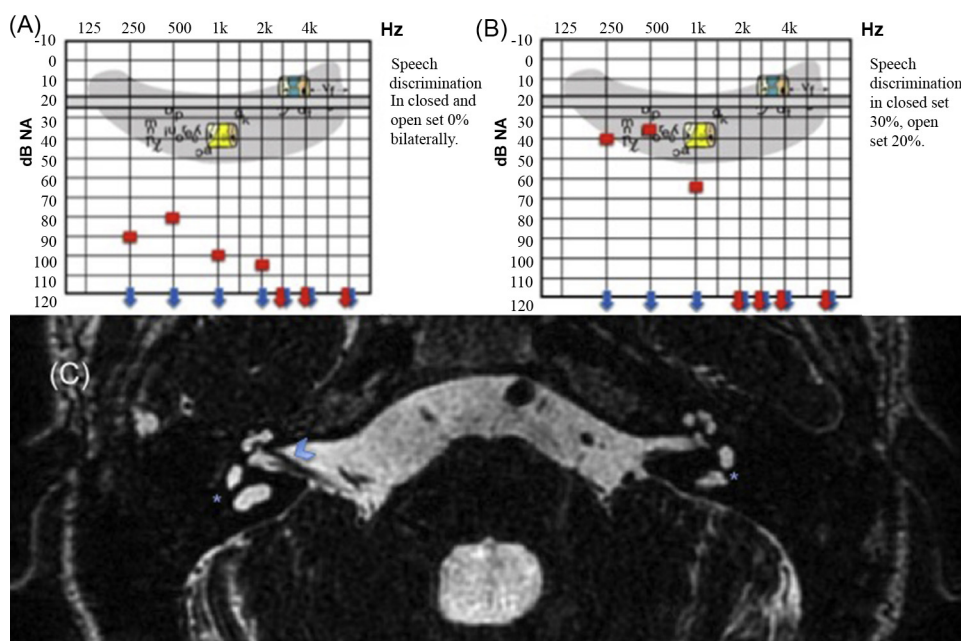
Audiometric and MRI findings prior to cochlear implantation. (A) Audiometric results without hearing aid. The patient showed no speech discrimination. (B) Audiometric results with a well-adapted hearing aid in the right ear. Speech discrimination thresholds in closed and open set are below 50%. (C) Axial MRI image of the right and left internal auditory canals showing a cochlear nerve in the right side (arrowhead) and absence of the cochlear nerve in the left, which correlates with auditory findings. The ★ shows the hypoplastic cystic labyrinth bilaterally. dB = decibel, Hz = hertz.
